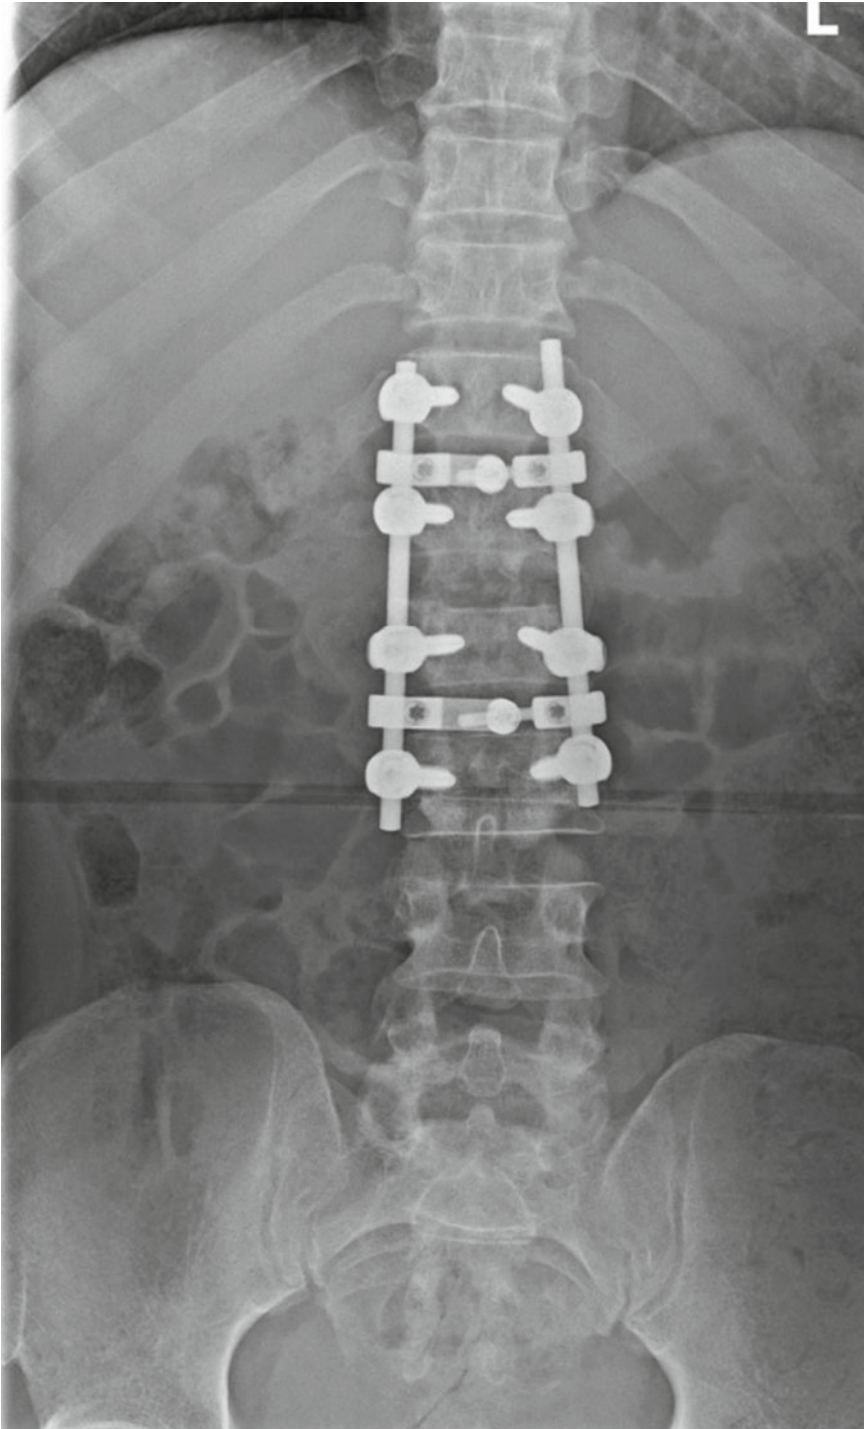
AP radiographs showing anterior instrumentation systems (Courtesy of Shibu P. Krishnan, London, UK)
